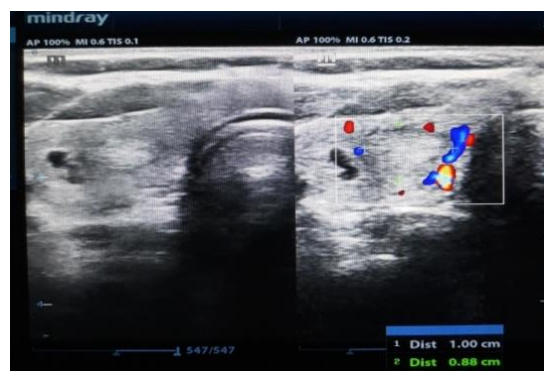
Ultrasound image of TI-RADS 3 hyperechogenic nodule with vascular periphery wall
